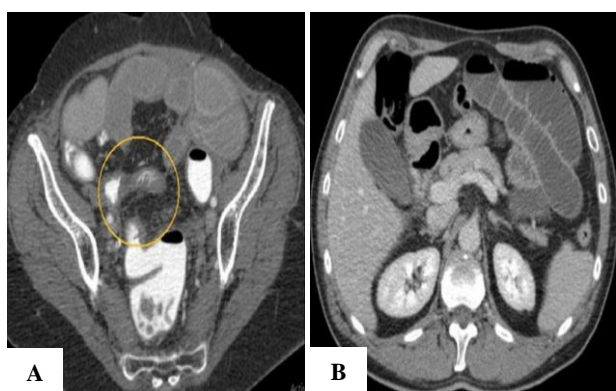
(A) CT scan of 57 year male showing adhesion band (circle) as a cause of obstruction, (B) Adhesion bands resulting in closed loop obstruction of small bowel.
